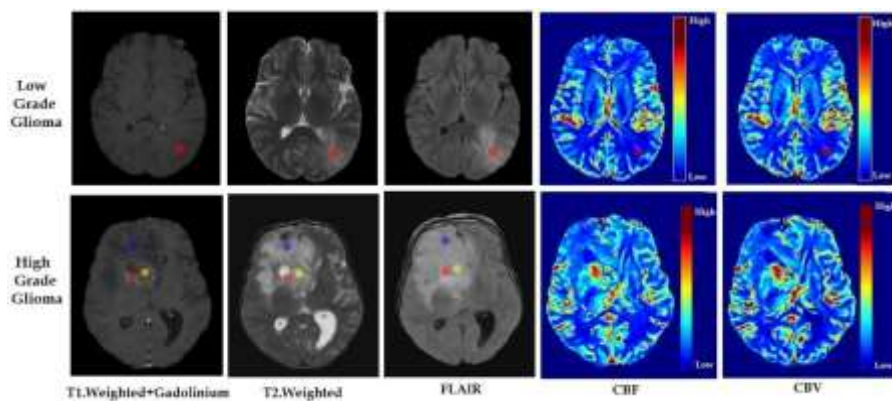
MR images of glioma patients. ROIs were placed on contrast enhancement (red), tumor core (yellow) and peritumoral edema (blue) regions of high-grade tumor and contrast enhancement region of low-grade tumor.
